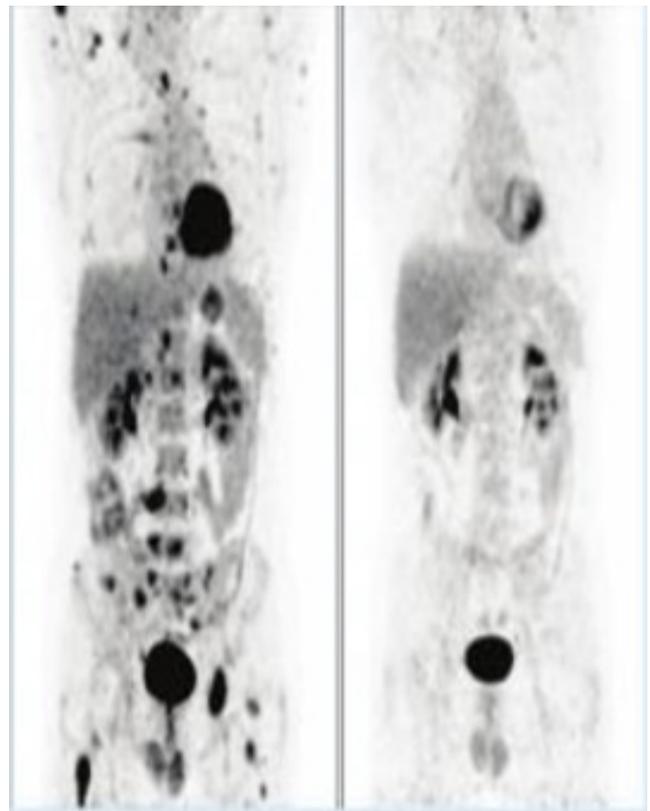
Complete metabolic regression of disease on control the 18F-FDG PET / CT examination. Left image-baseline 18F-FDG PET / CT revealed widely spread disease (axillary, mediastinal, retroperitoneal, para iliac and inguinal lymph nodes, right humerus, ribs, left and right femur). The right image-follow up 18F-FDG PET / CT indicates metabolic regression after immunotherapy
